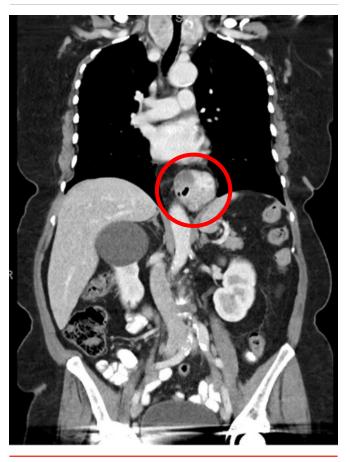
Abdominal CT Scan. Published with Permission
